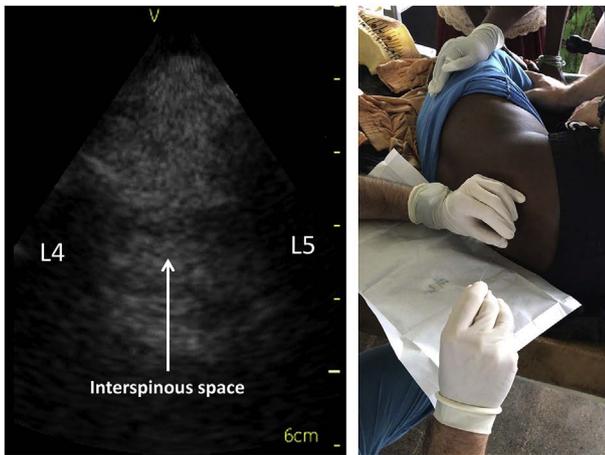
Ultrasound guided lumbar puncture performed on 14 years old boy with suspected meningitis.
